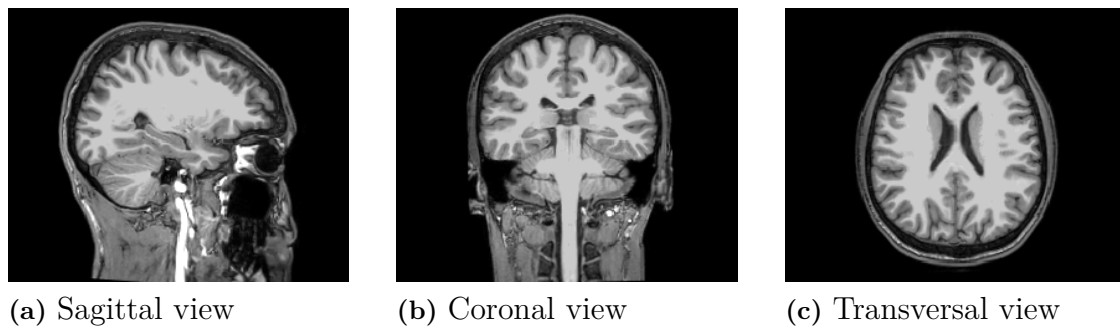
Figure showing single slices of an MRI along the three principal anatomical planes: (a) Sagittal, (b) coronal and (c) transversal
